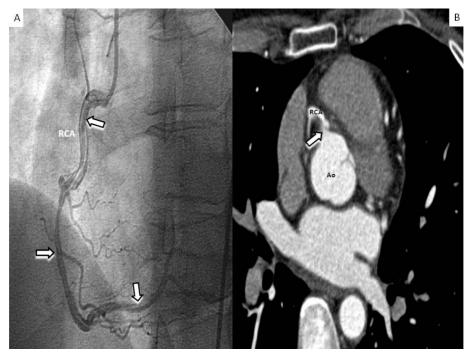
A: Left anterior oblique view (45°) showing a spiral dissection in the proximal to distal segments of the right coronary artery (arrows) B: Computed tomographic (CT) angiograms of the thoracic aorta: demonstrated the presence of dissection of the RCA without involvement of the proximal aorta. RCA: right coronary artery. Ao: aorta.
